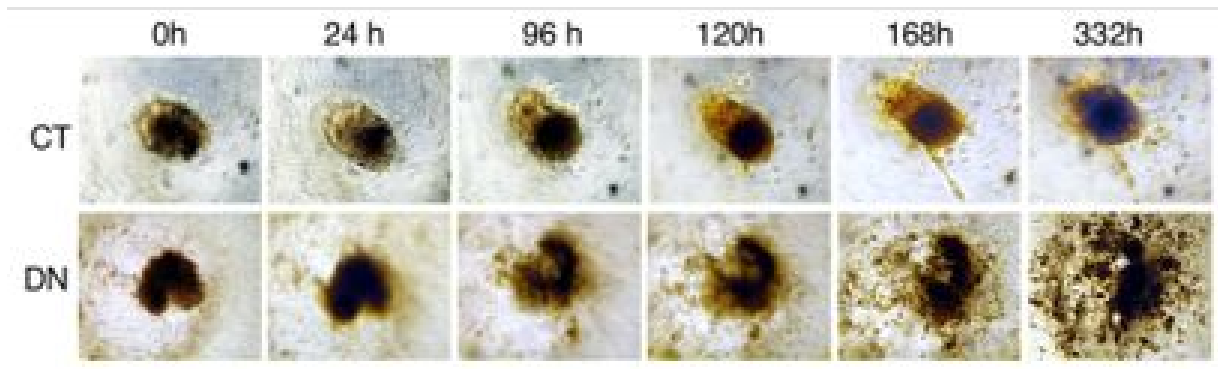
Collagen invasion assay of the most aggressive RCM-Subtypes. CT and DN melanoma biopsies were digested, and cells were seeded in hanging drop culture to obtain spheroids. 72 h after seeding, spheroids were transferred in a type I collagen matrix and pictures were taken from 0 to 332 hours.
